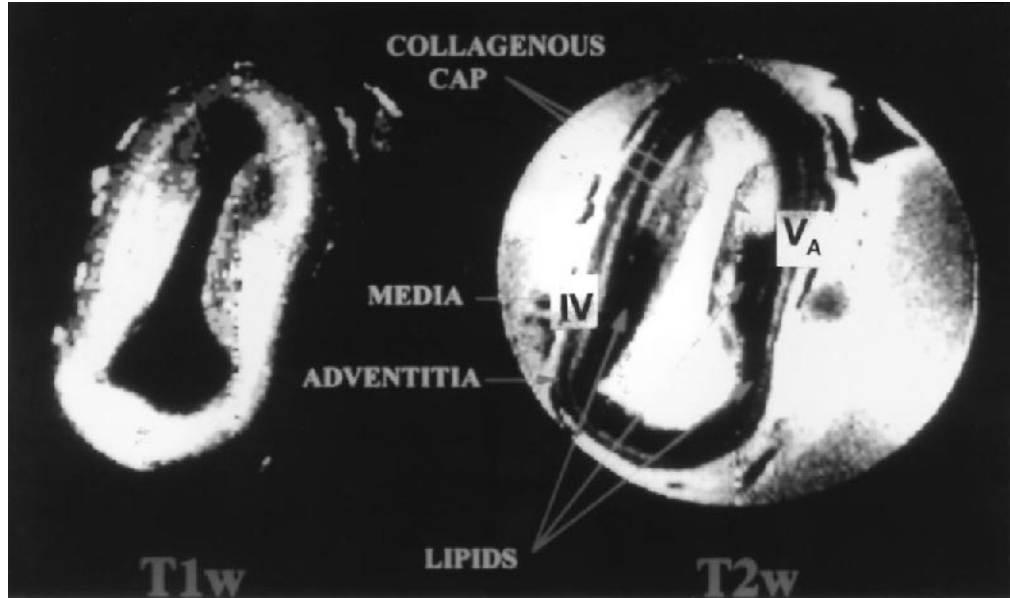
Nuclear magnetic resonance images of vulnerable or unstable lesions. T2w image identifies a collagenous cap on both plaques. In the type V lesions (right), the cap completely covers the lipid core. In the type IV lesions (left), the plaque is only partially covered, and infiltration of fat is more diffuse. (Modified, with permission, from Ref. 179.)
